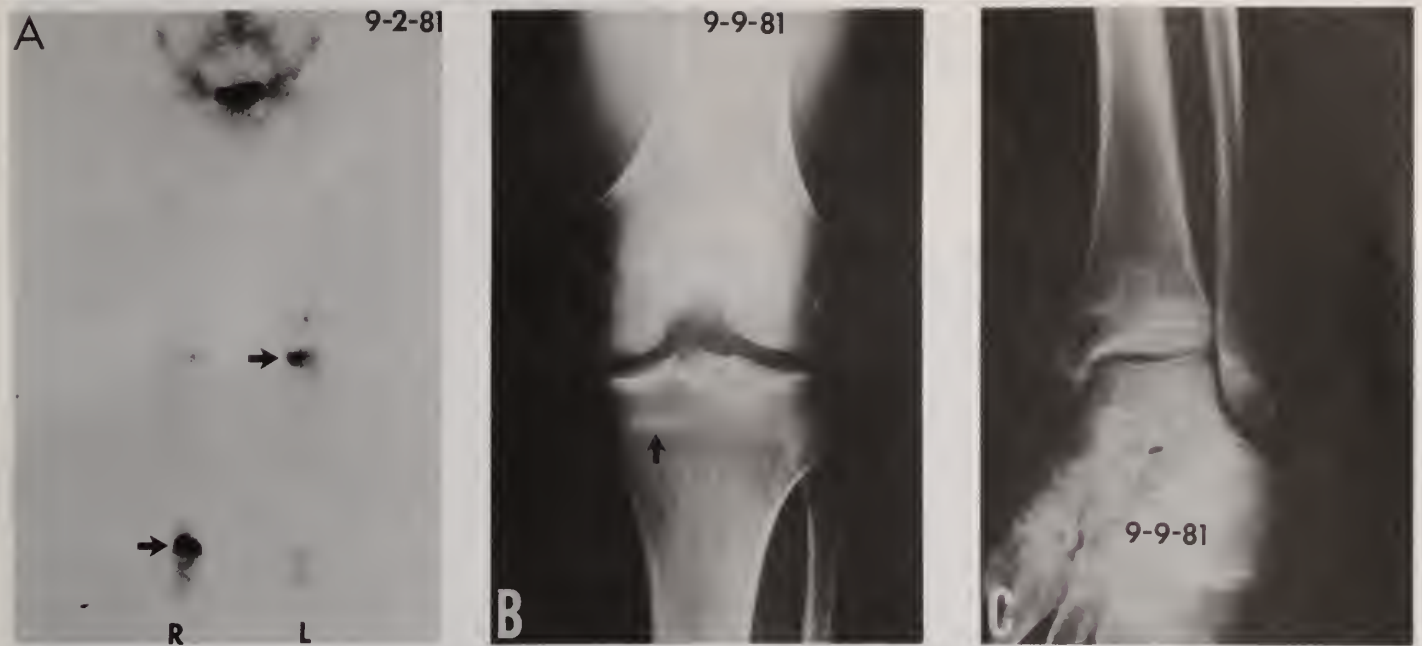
Bone scan (A) demonstrates intense uptake in the left medial tibial plateau and distal tibia (arrows). Radiographs (B and C) were normal initially and when repeated one week after the bone scan, demonstrate sclerotic changes (arrows) in the corresponding areas of abnormal uptake in the bone scan.
